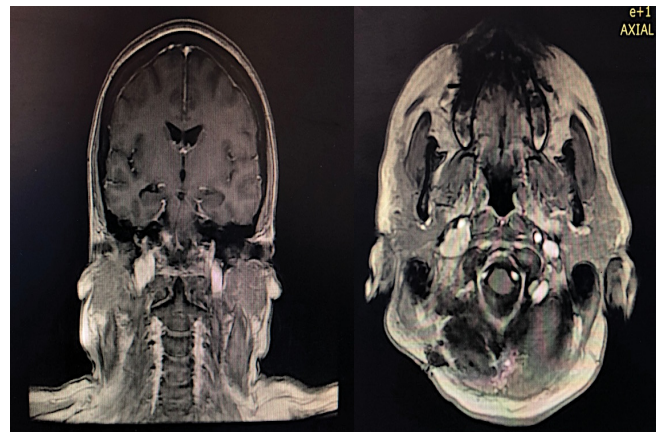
Postoperative MRI showed a residual lesion outside the jugular foramen.
